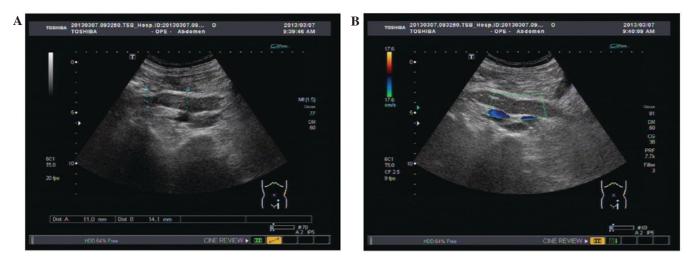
Ultrasound scans revealed that the mass, which was located in the middle-lower of the left ureter and measured 70x15x15 mm, exhibited (A) an iso-echo signal with (B) no distinct color doppler flow signal.
